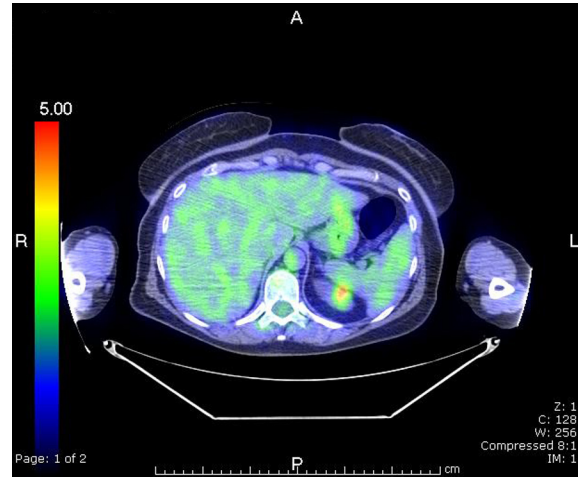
Mass in the superior pole of the left kidney demonstrates abnormally increased FDG uptake (FDG-PET, 2013).
